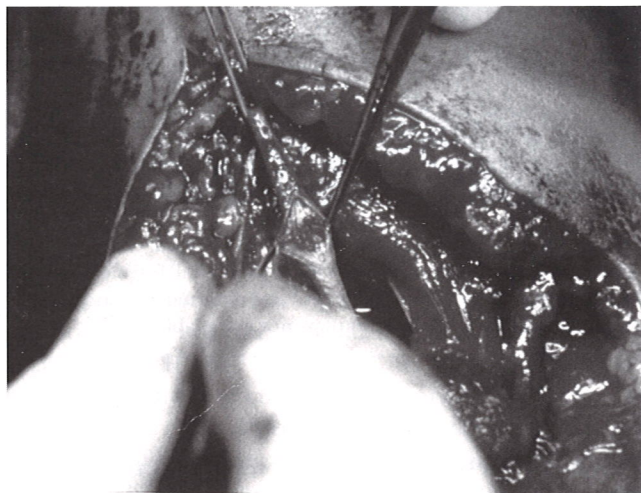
Arterial exploration identified an intimal tear with thrombus formation in this child with a supracondylar fracture and a nonviable hand (no palpable or Doppler pulse).
